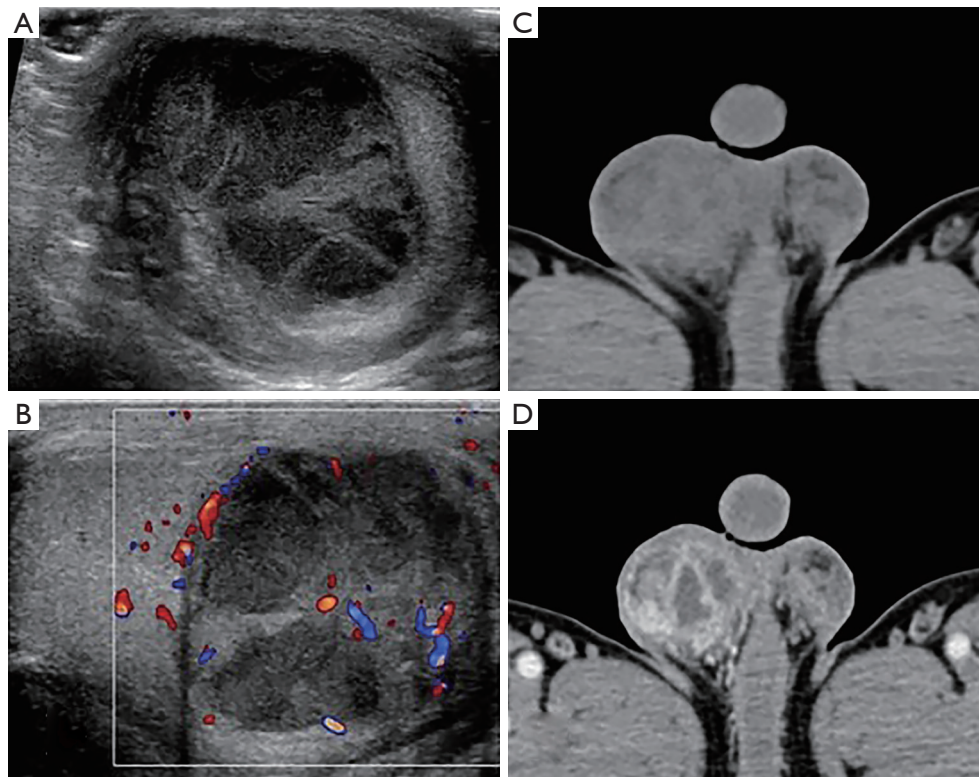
A 62-year-old man presented with right-sided painful scrotal mass. (A) Grayscale of the right testis demonstrates a mixed and cystic lesion with septa. (B) CDFI shows blood flow in the solid part of, and around, the mass. (C) Pelvic CT shows an obscure heterogeneous lesion in the right testis. (D) The lesion was multilocularly significantly enhanced. CDFI, color Doppler flow imaging.
